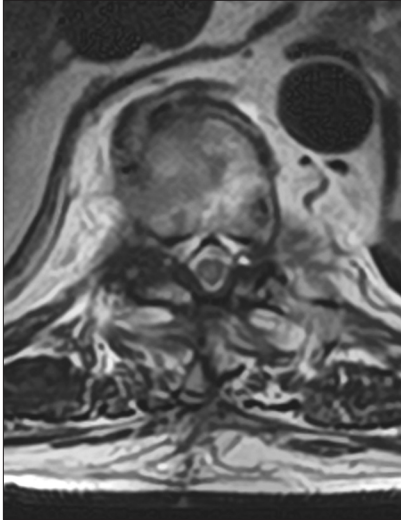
Postoperative image of MRI. Cyst removal and spinal decompression are confirmed.
